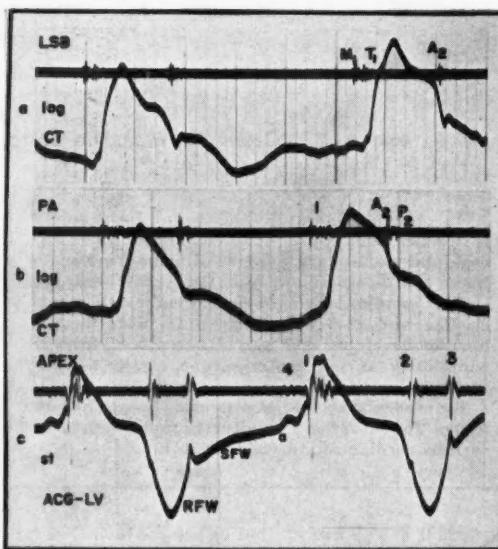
Phonocardiograms, normal subjects. (a) Physiological splitting of the first sound. Note that both components (M_1 preceding T_1) precede the initial rising in the CT. (b) Physiological splitting of the second sound. The aortic component (A_2) precedes the dicrotic notch of the CT by 0.03 second. The pulmonic component (P_2) which has a smaller amplitude in comparison with A_2 follows the dicrotic notch of the CT by 0.01 second. (c) Quadruple rhythm. Fourth sound preceding M_1 by 0.09 second and is coincident with the peak of the "a" wave in the ACG (atrial contraction) and third sound following A_2 by 0.15 second is coincident with peak of rapid filling wave (RFW) in the ACG. A_2 precedes the beginning of RFW by 0.07 second.
